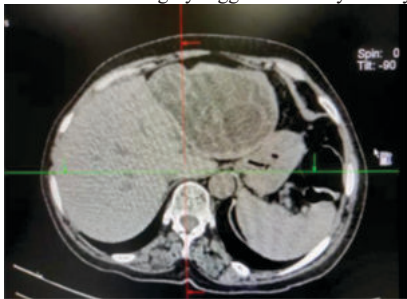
Fig a- CT Image Showing Hydatid Cyst
